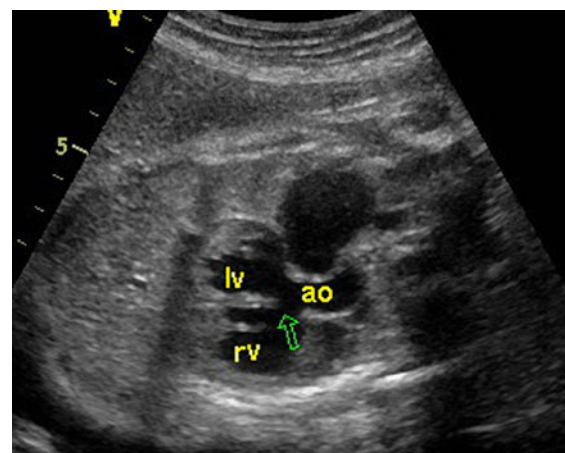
Fetal echocardiography showing overriding of the aorta, a subaortic ventricular septal defect, and an aneurysmatically dilated pulmonary artery
